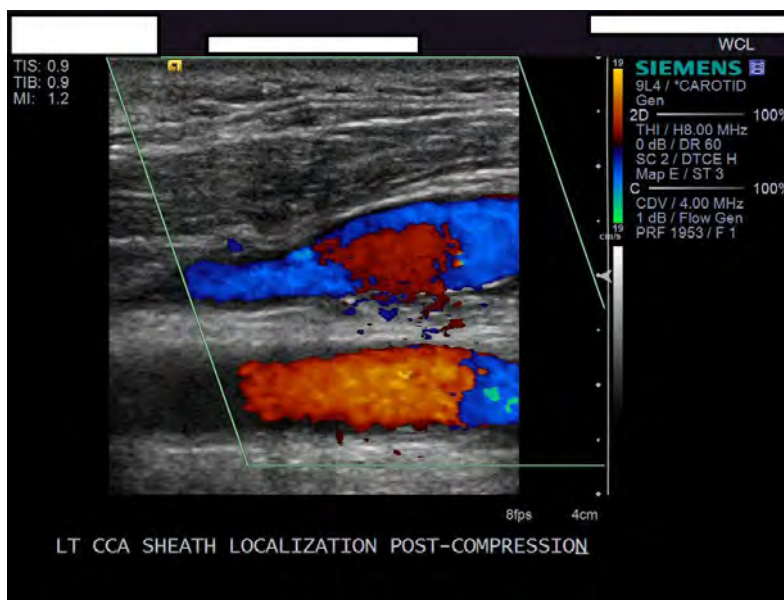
Internal Jugular and Carotid Artery After Removal of Venous Sheath and Ultrasound-Enabled Compression
